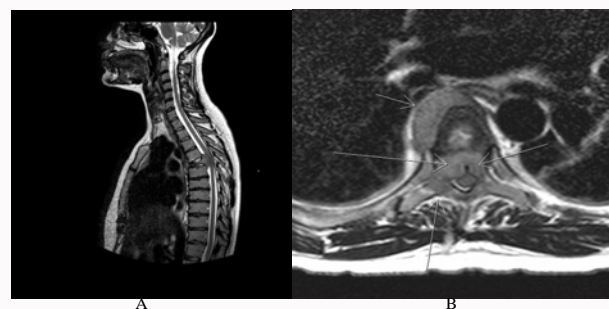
T1 postcontrast MRI sagittal image (A) showing T5 pathologic fracture with greater than 50% loss of height, with tumor involvement of the posterior elements (A), as well as the corresponding post-contrast axial image (B) through T5 showing right-sided pedicle involvement with circumferential extension into the epidural space.
